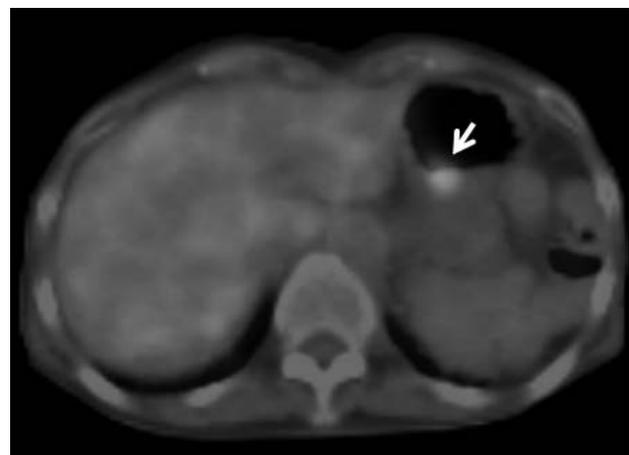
Positron emission tomography/computed tomography (CT) scan. The positron emission tomography/CT scan shows uptake of fluorodeoxyglucose at the posterior gastric wall (arrow).
